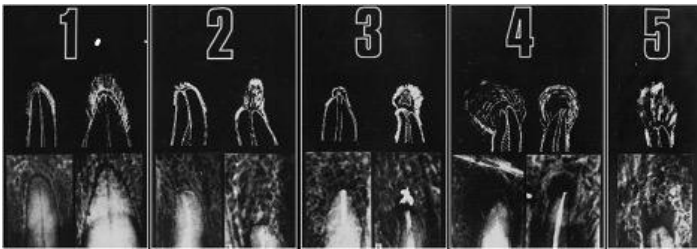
The reference radiograph used for evaluating the roots with PAI.¹³
